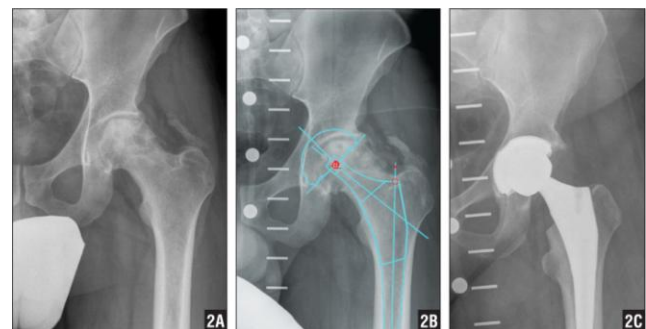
Preoperative hip radiograph (A), preoperative digital template using the newly designed KingMark (Double Markers) method of templating (B), and postoperative hip radiograph (C) of a patient who received a Left Total Hip Replacement
